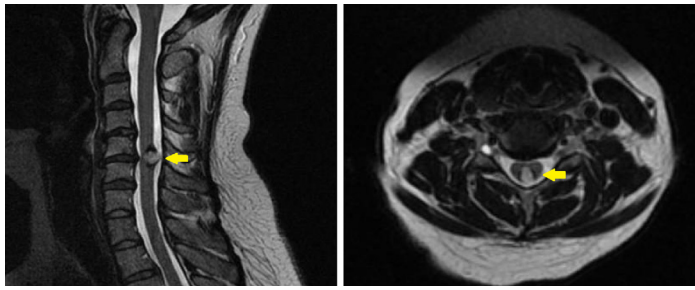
Sagittal (left image) and Axial (right image) T2-weighted MRI showing an exophytic mixed signal intensity lesion in the posterior aspect of the C5-C6 spinal cord segment (yellow arrow), with a surrounding hypointense rim of hemosiderin suggesting a cavernous malformation.
